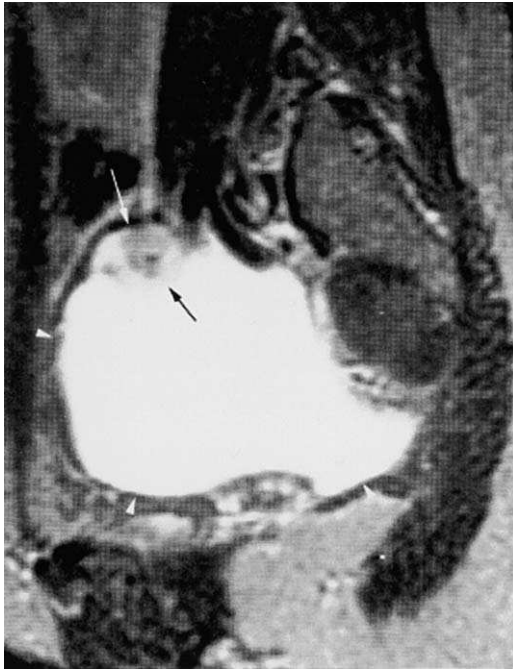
Peritoneal retention cyst in a woman with a history of pelvic surgery. T2-weighted image shows a cystic mass (arrowheads) adjacent to the ovary (arrows). The pelvic wall and the ovary bound the border of the lesion.
